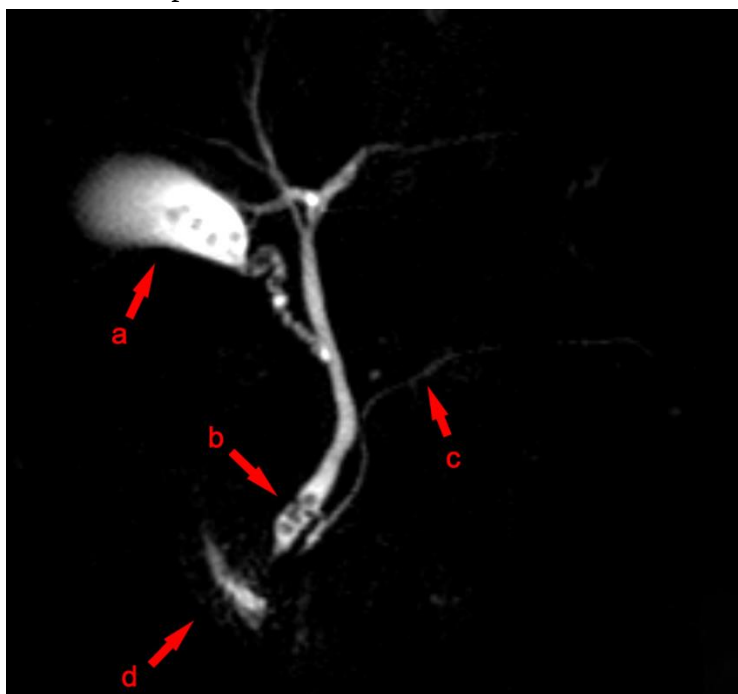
Magnetic resonance cholangiopancreatography (MRCP) in mechanical jaundice due to choledocholithiasis. The MRI image (T2-weighted) shows an enlarged common bile duct and an intraluminal filling defect - a stone (b - arrow points to the concretion in the common duct). Concretions are also noted in the gallbladder (a), while the pancreatic duct is not dilated (c).
